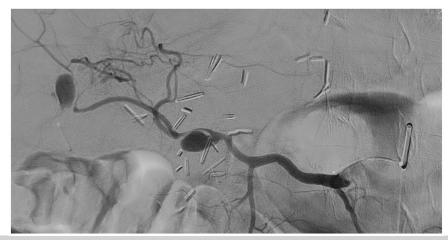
A, Conventional angiogram revealing an outpouching 4-mm aneurysm (*arrow*) from the transplant hepatic artery at the site of anastomosis. B, Conventional angiogram performed after 2 weeks showing the aneurysm has increased to 15 mm. C and D, Computed tomography (CT) angiogram performed after 2 weeks showing the aneurysm has increased in size (*horizontal arrow* indicates the aneurysm; and *vertical arrow*, the tortuous hepatic artery).
